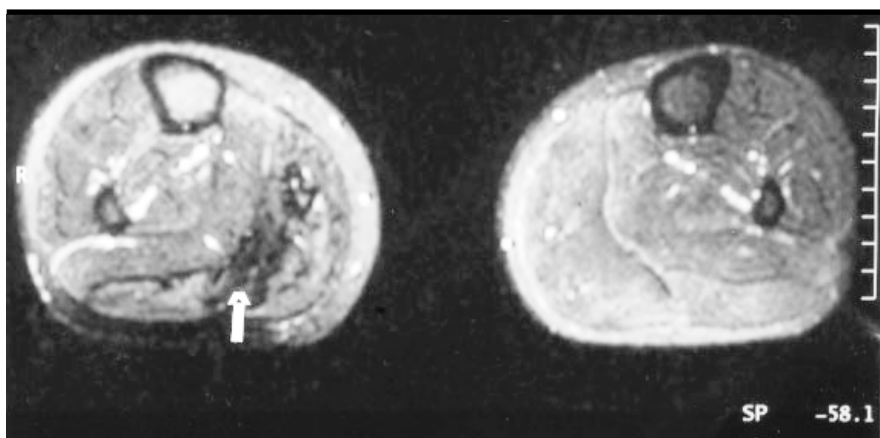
MRI of the legs showing hypointense areas (arrow) on the back of the right leg due to fibrosis of the sural muscles.
